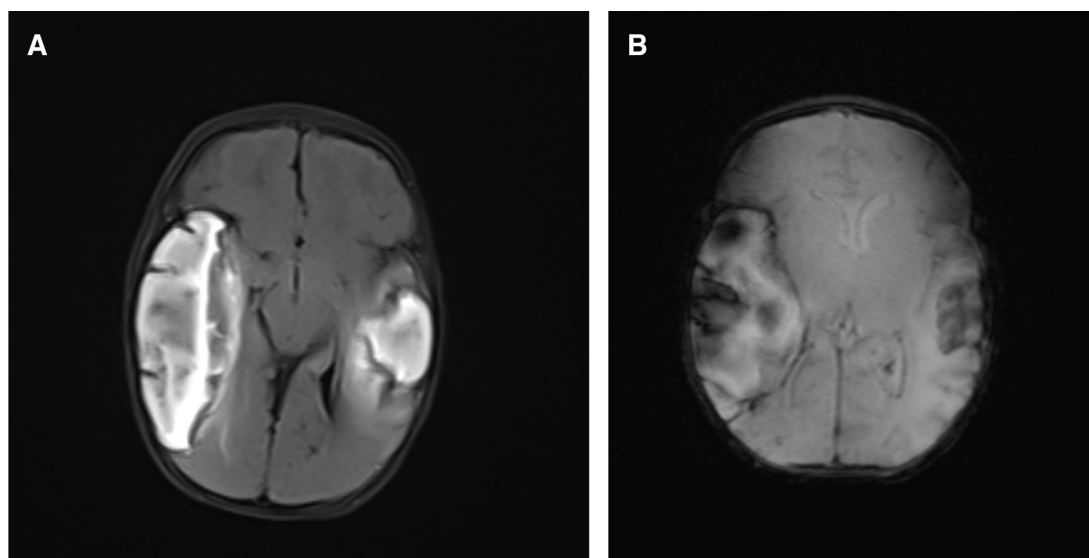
(A) Axial Ffluid A-attenuated inversion Rrecovery (FLAIR) shows bilateral multiple extensively hyperintense lesions at frontal temporal regions shown on MRI. (B:) Axial Ffast Ffield Echo (FFE) shows bilateral frontal temporal lesion with blooming artefacts in keeping with areas of cerebral haemorrhages in MRI.
